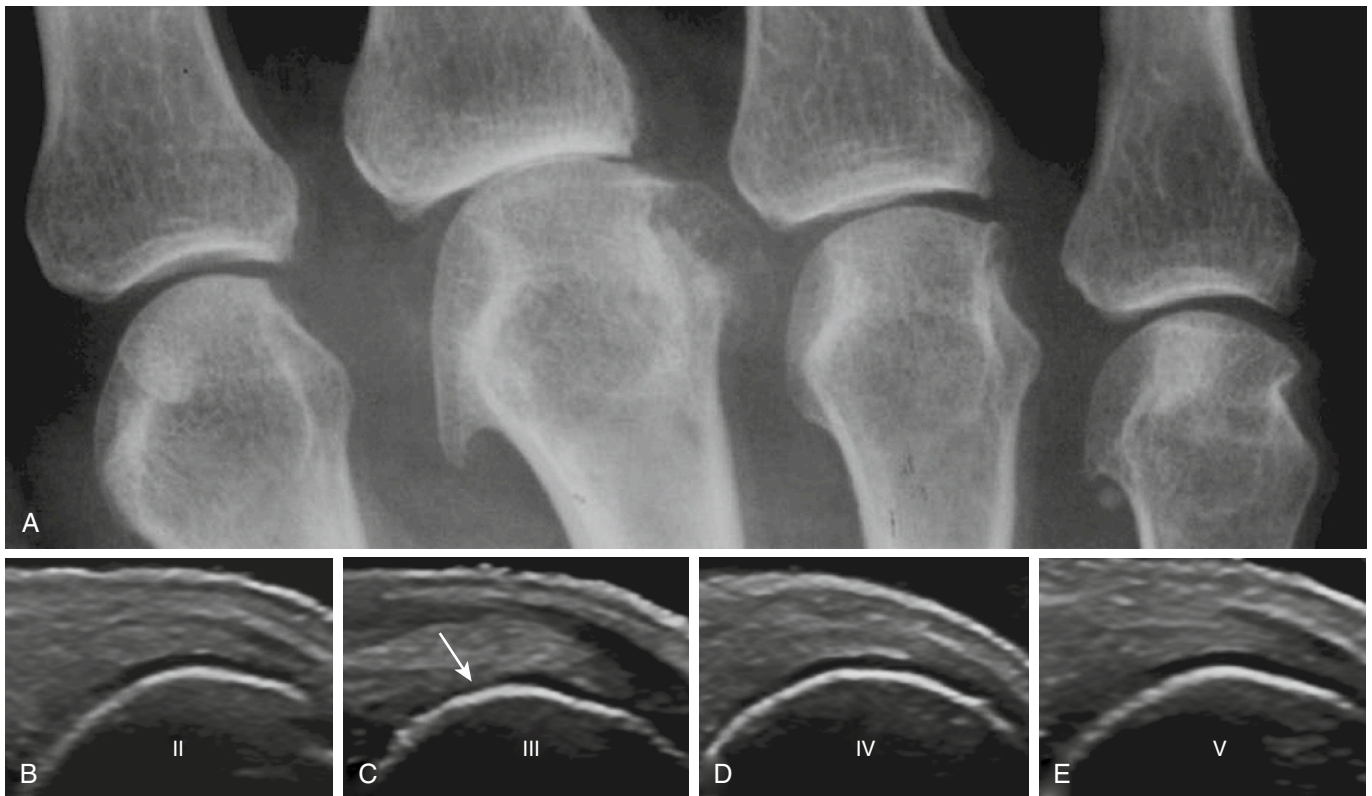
OSTEOARTHRITIS OF THE HAND. A, A posteroanterior radiograph shows the II to V metacarpophalangeal joints. B-E, Dorsal sonographic images were obtained for the metacarpal heads of the II (B), III (C), IV (D), and V (E) fingers, with the metacarpophalangeal joints in maximal flexion. The hyaline cartilage thickness was 0.5 mm at second and fourth metacarpal heads and 0.4 mm at the fifth metacarpal head. Focal thinning of the cartilage layer was found at the III metacarpal head. The *arrow* indicates an area of the cartilage layer that was 0.1 mm thick.
